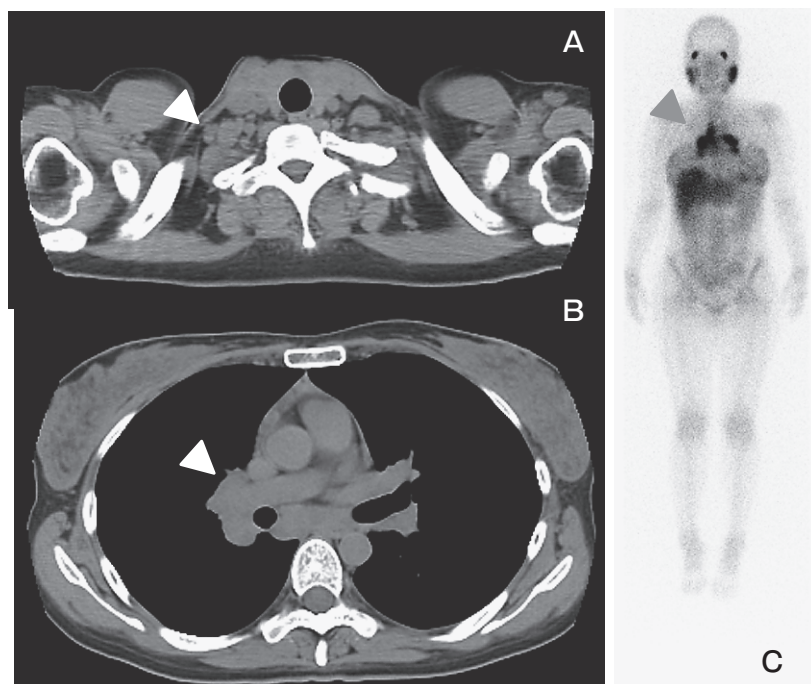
Chest computed tomography revealed bilateral parotid gland swelling, and right supraclavicular (A), mediastinal, and hilar lymphadenopathy (B), which displayed a high accumulation of gallium during scintigraphy (C).
